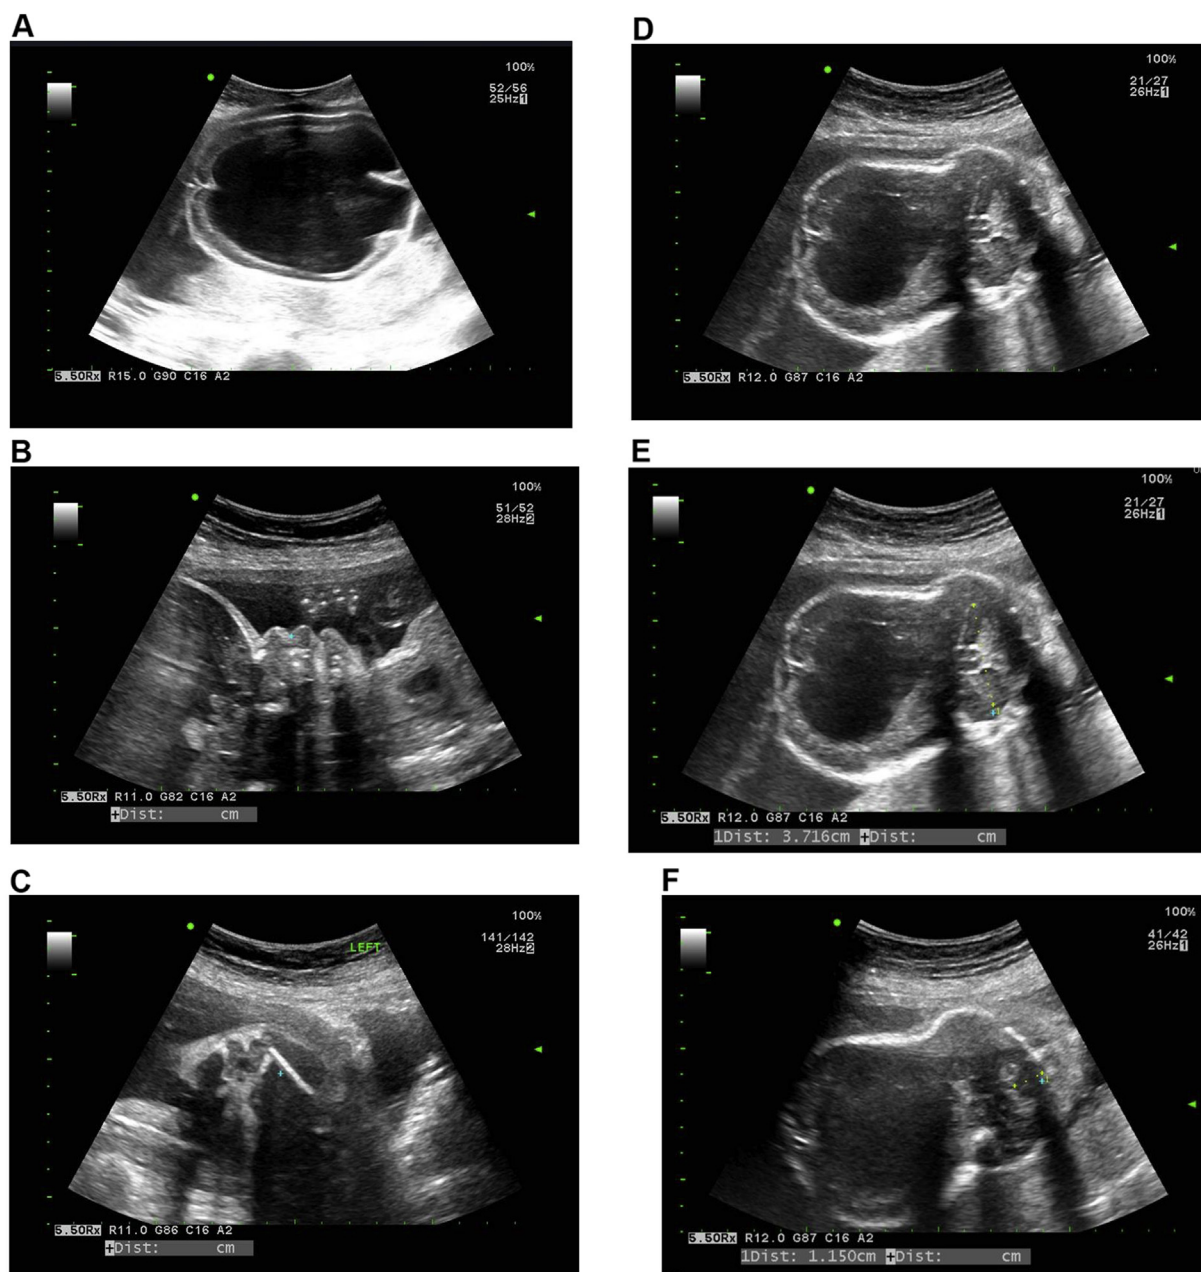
Prenatal ultrasound at 25 weeks of gestation shows (A) hydrancephaly, (B) frontal bossing and a depressed nasal bridge, (C) short straight limbs, (D) a cloverleaf skull, (E) cerebellar enlargement and (F) an enlarged cisterna magna.
